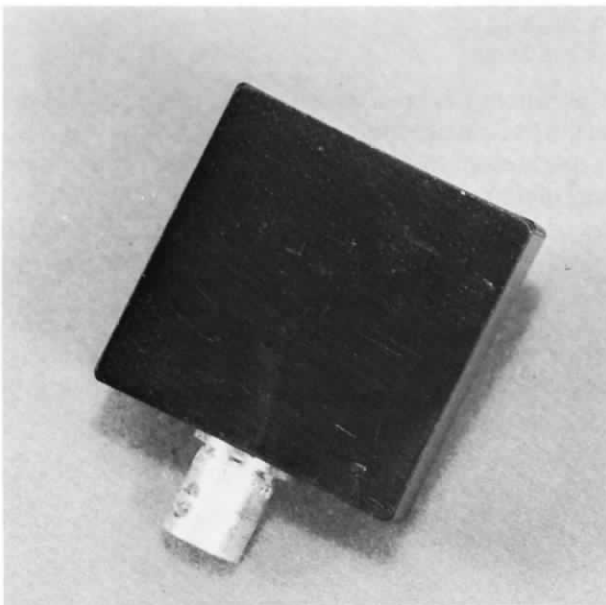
X-ray waveform monitoring test setup. The detector is a small box containing solid-state detectors with its output passing through the BNC connector.
